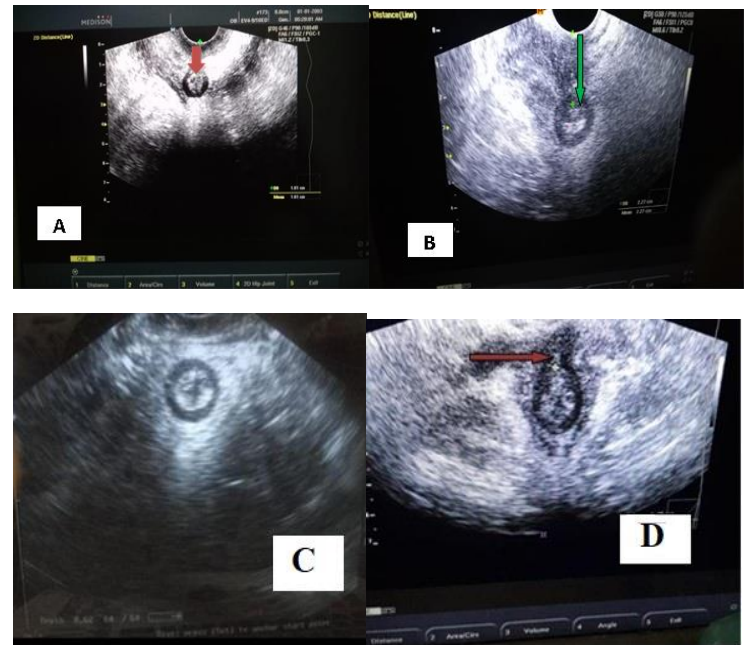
(A) Anovaginal distance in women with OASIs, (B): Anovaginal distance in women without OASIs. Postpartum ultrasound EAS assessment (C): An intact external anal sphincter, (D): A torn external anal sphincter (site of tear shown at the cursor).
